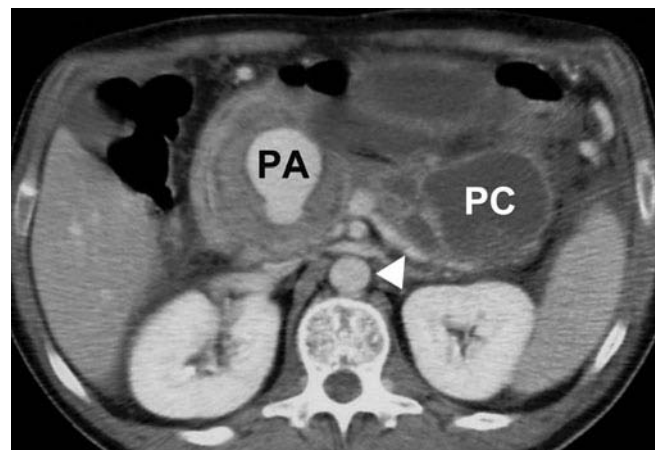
Recurrent pancreatitis. CT shows a pseudocyst of the pancreatic tail (PC) and a pseudoaneurysm of the gastroduodenal artery (PA). The splenic vein is indicated by the arrowhead
